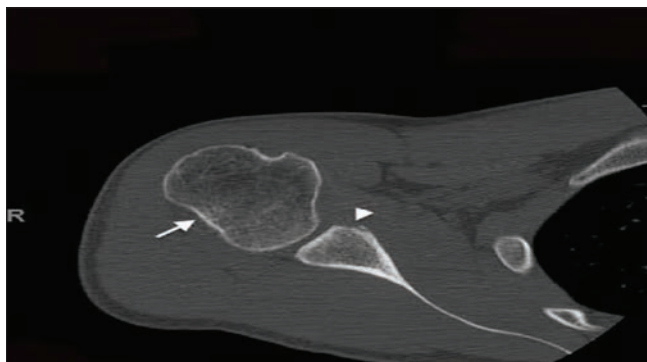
Preoperative axial computed tomography shows glenoid bone loss (White Arrow Head) and Hill Sachs lesions (White Arrow)
